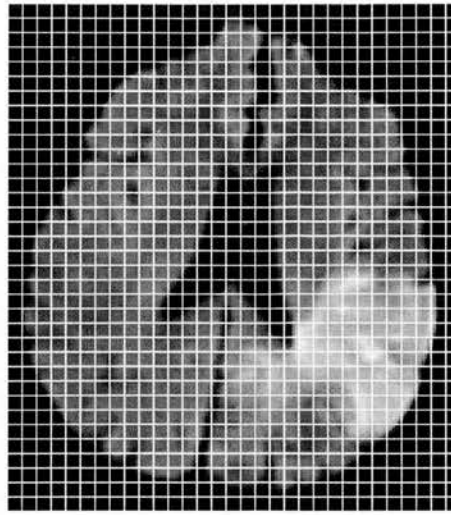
Manual grid analysis example image (Patient A, left hemisphere ischaemic lesion on DWI at 4 hours after stroke onset). Each grid box is 4.69×4.69 mm.
